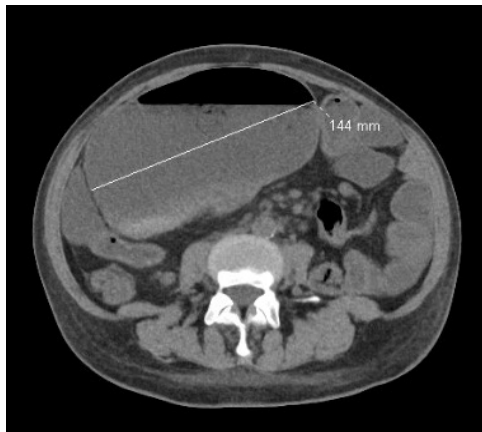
CT showing 14cm dilation of cecum prior to ileocecectomy.
